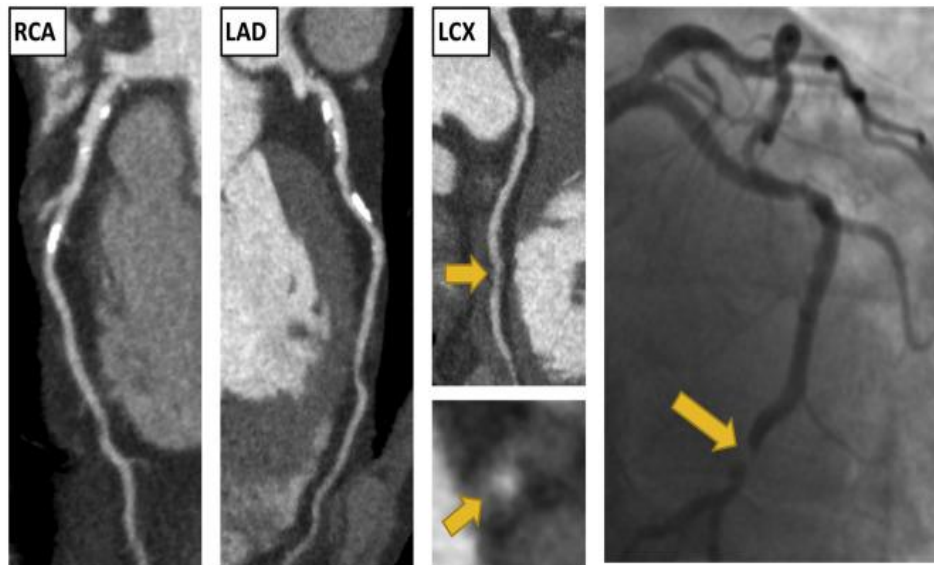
Computerized tomography (CT) angiogram for acute coronary syndrome [29]
